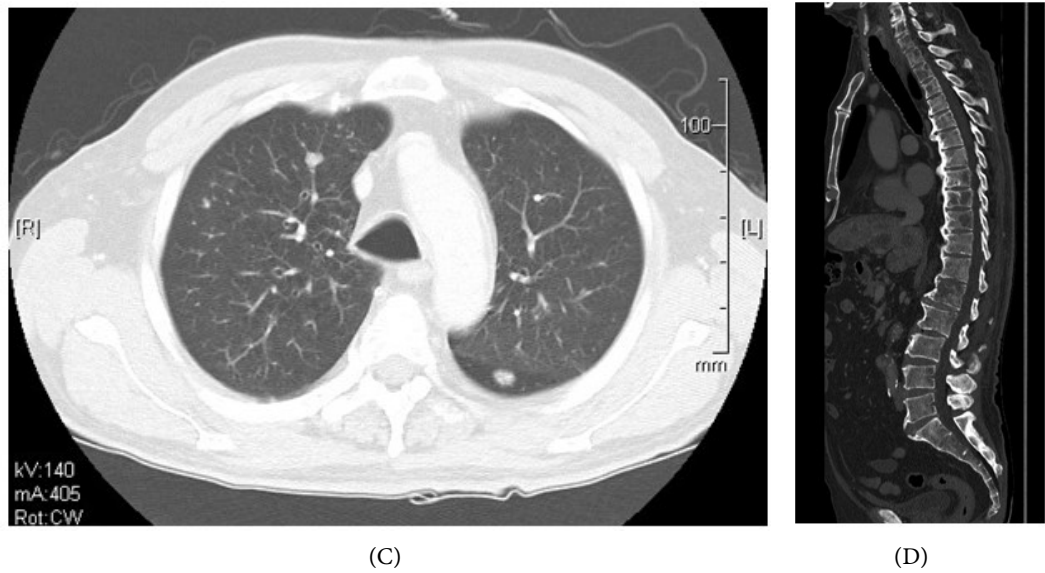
Computed tomography examination image of the diagnosis. (A) numerous tumors with contrast effects were observed in the liver. (B) an 8-cm cystic mass was observed in the left kidney. The margins of the cystic mass were marked with an irregular contrast effect. (C) multiple nodules were observed in both lungs. (D) multiple bone metastases were observed in the spine and pelvis.
